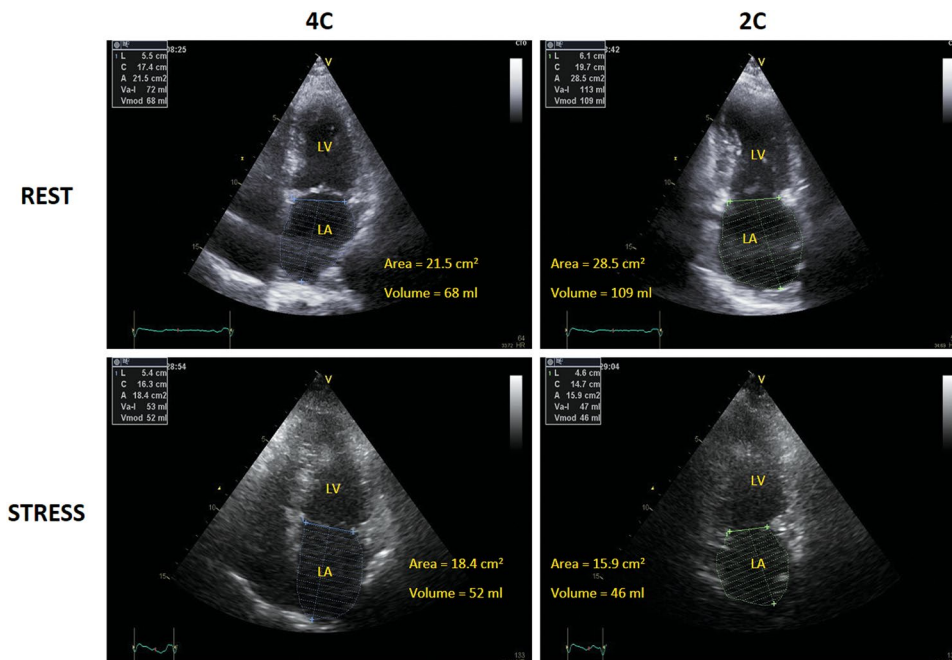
An example of LAV reduction during stress. Apical 4-chamber (left panels) and 2-chamber (right panels) views of a patient at rest (upper panels) and peak dobutamine stress (lower panels). LAVI volume decreases >20% at peak stress. LA left atrium, LV left ventricle
